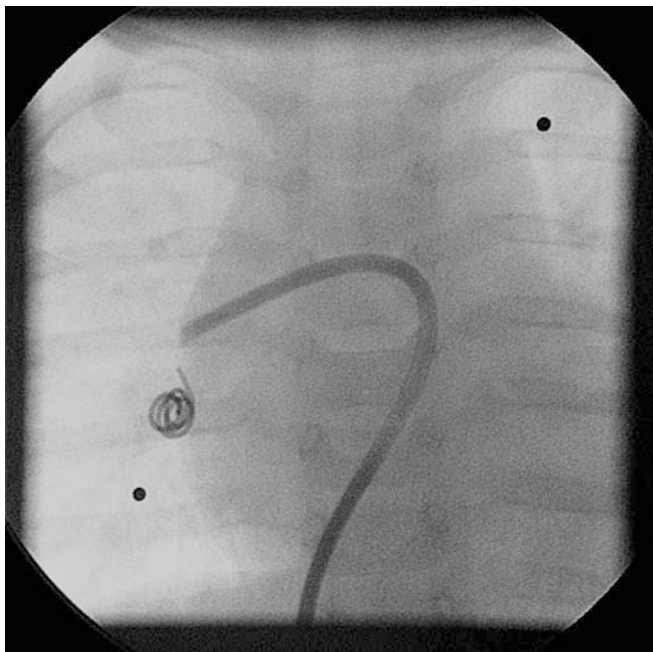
Posterior-anterior chest X-ray film showing the embolised Cook detachable coil in the right pulmonary artery. A 6 F long sheath was introduced into the right pulmonary artery and the Cook detachable coil was retrieved into the sheath using a snare catheter. Afterwards the sheath was used to implant the ADO
